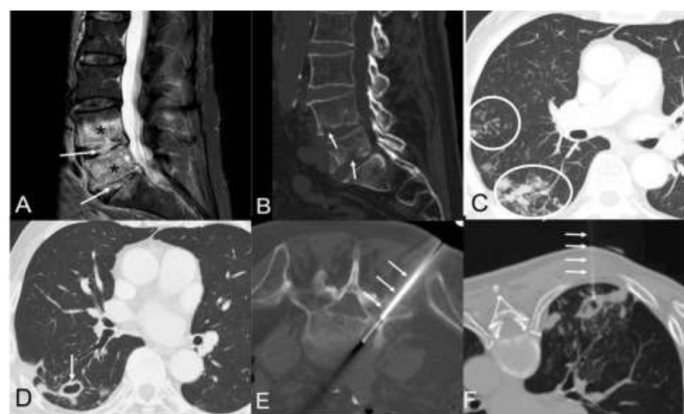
A) Sagittal MR image of the lumbar spine (STIR sequence) showing a marked alteration in the signal intensity of the intervertebral discs L4-L5 and L5-S1 (arrows) and the adjacent vertebral endplates (asterisks). B) Sagittal reconstruction of lumbar spine CT (bone window) which shows the bone erosions of the vertebral endplates (arrows). C) and D) Axial CT images of the chest (lung window) showing centrilobular lung nodules and "tree-in-bud" images (C, circles) and a dominant thin-walled cavitory lesion (D, arrow). E) Axial CT image of the lumbar spine (bone window, patient placed in the prone position) showing the percutaneous biopsy (arrows) of disc infection foci. F) Axial CT image of the chest (lung window, patient placed in the prone position) showing saline instillation into a cavitory lung lesion (arrows). After the instillation of 10 ml of saline, only 1 ml of fluid could be aspirated, although the patient expectorated abundant sputum (15 ml) at the end of the procedure.
